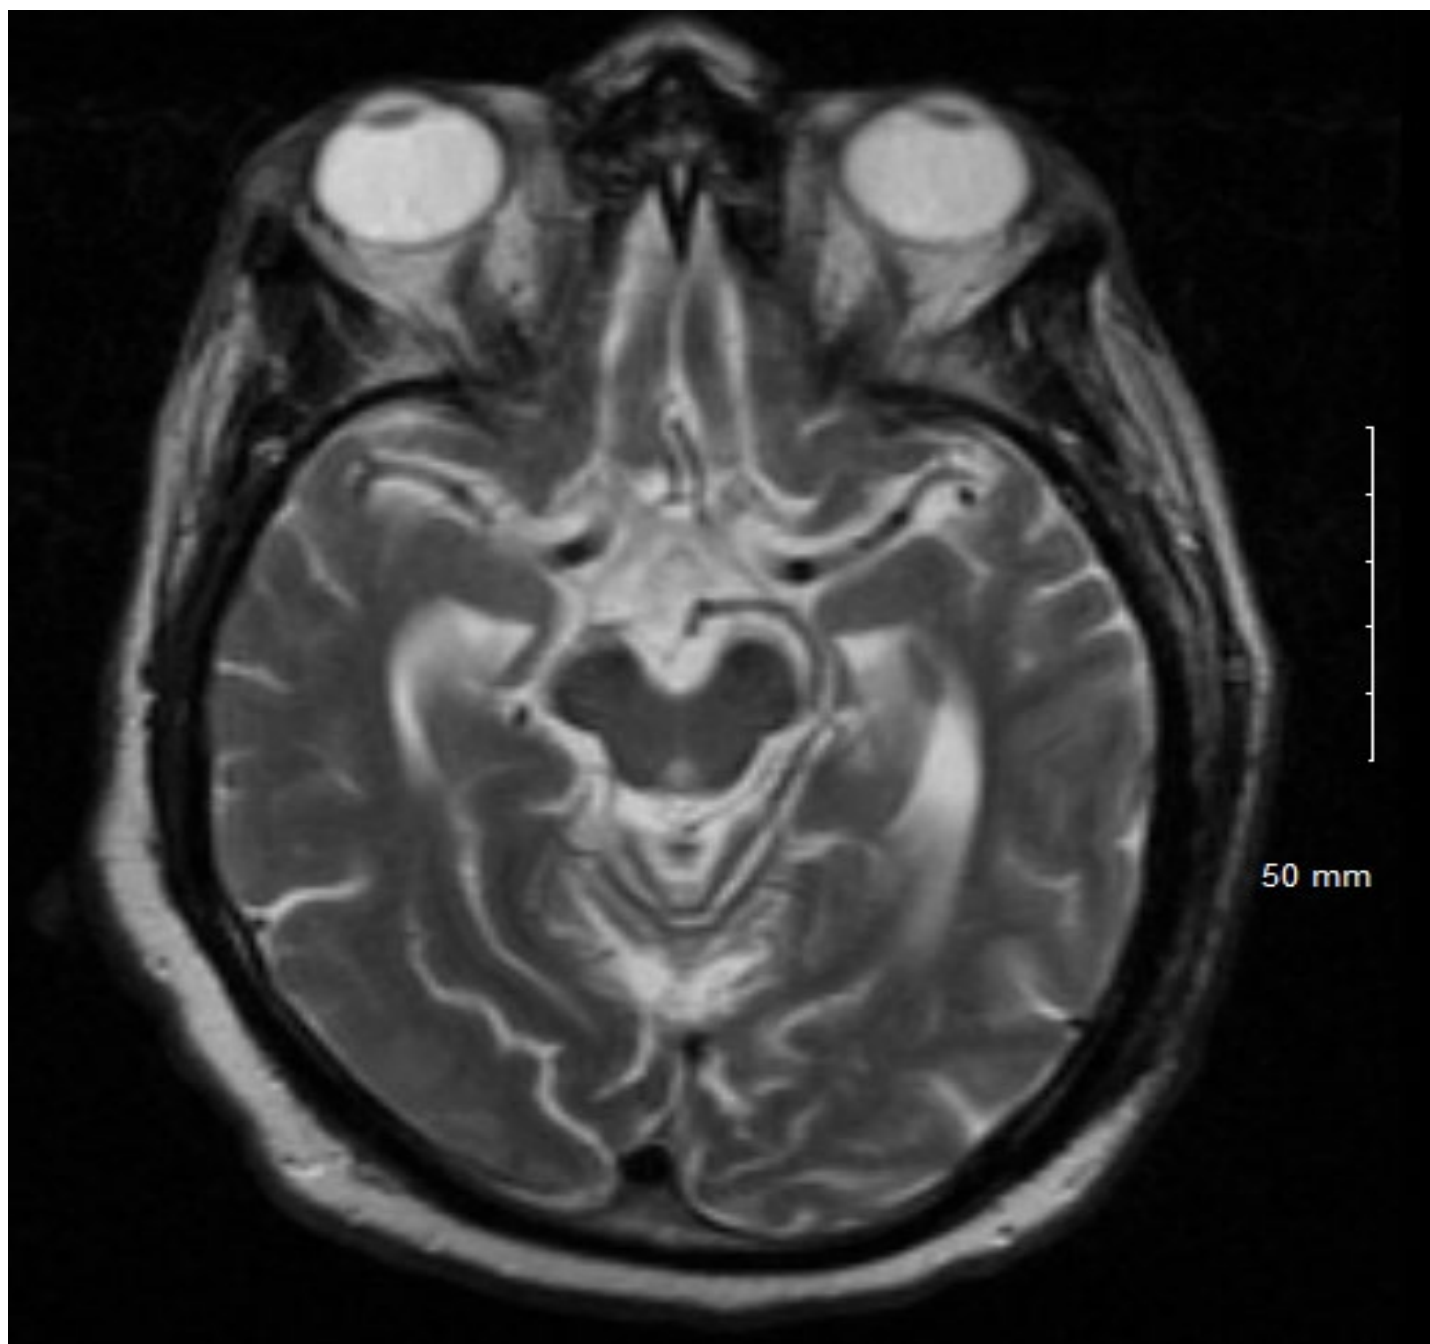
T2 weighted MRI shows hyperintensity in the left frontoparietal area (right side of figure) and left hemi-craniotomy and cranioplasty.
